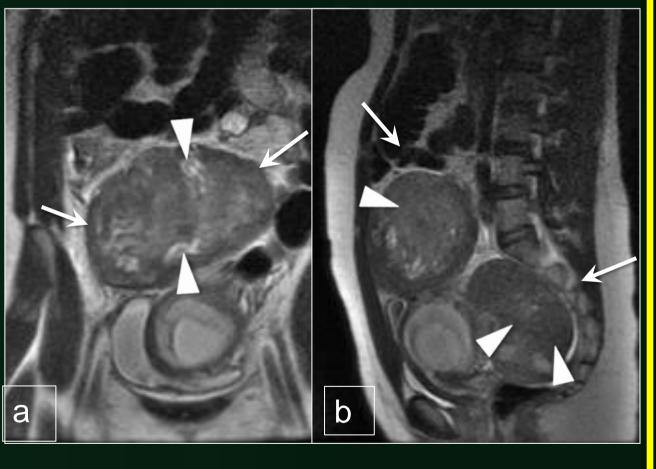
Degenerating leiomyomas. Coronal (a) and sagittal (b) T2-weighted SSFSE images demonstrate two pedunculated uterine leiomyomas (arrows) with internal foci of high T2 signal (arrowheads) indicative of degeneration.
